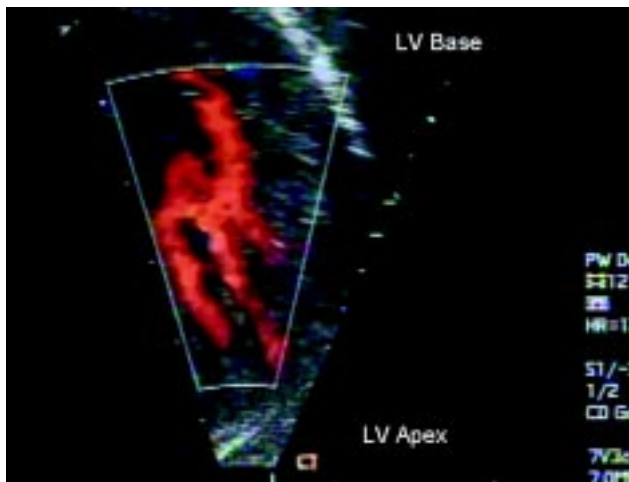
Color Doppler echocardiogram in apical 4-chamber view showing flow from the left ventricular cavity within the deep intertrabecular recesses.
